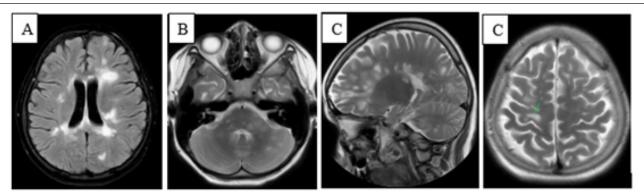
MRI Brain (2021) showed T2 FLAIR hyperintense lesions in both supra- and infratentoral brain A and B, Dawson fingers appearance of periventricular lesions (C) (Case 1).
